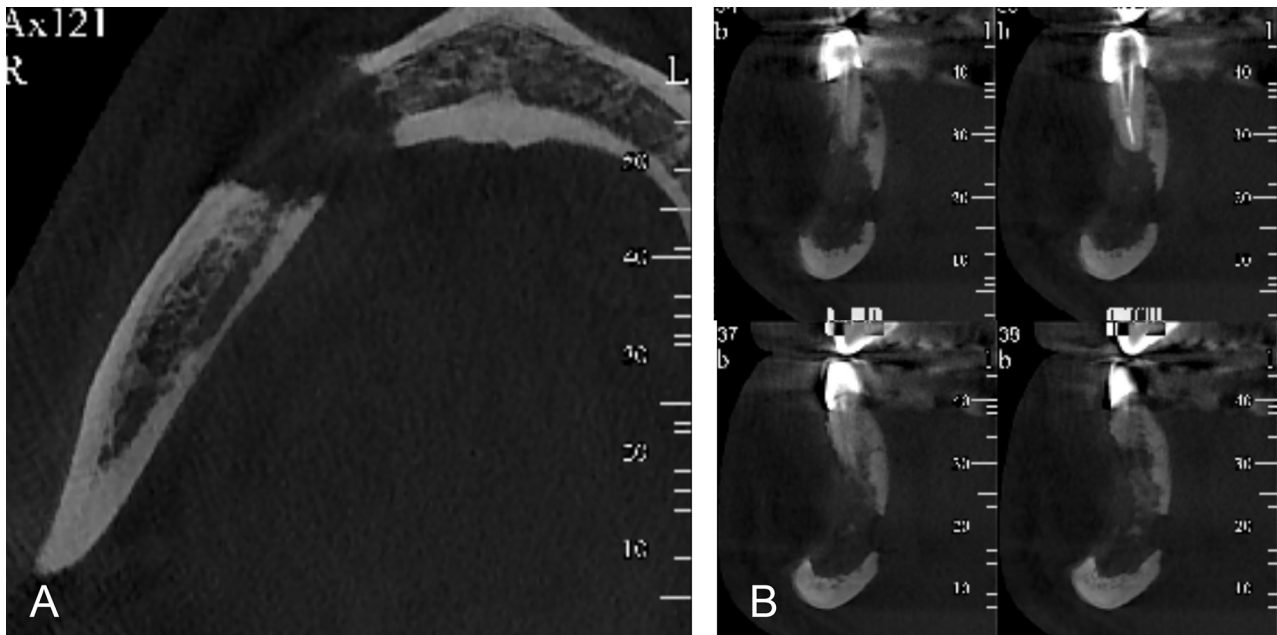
CT-scan of CCOC showing a bicortical invasion of the tumor.
